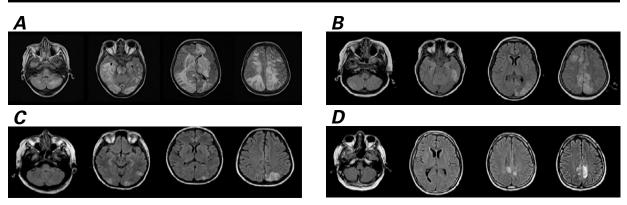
Diffusion-weighted magnetic resonance images in patients with posterior reversible encephalopathy syndrome show findings consistent with vasogenic edema: A) holohemispheric watershed pattern; B) superior frontal sulcus pattern; C) dominant parietal-occipital pattern; and D) partial or asymmetric expression of the primary patterns.
